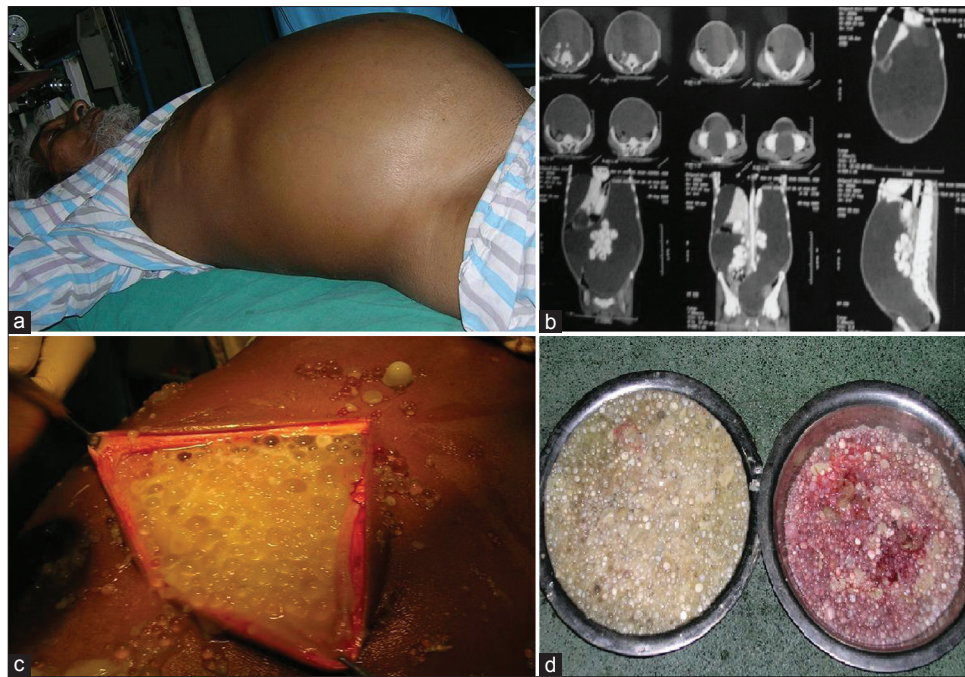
(a) Preoperative photograph of patient with symmetric enlargement of the abdomen, (b) Contrast-enhanced computed tomography (CECT) scan showing whole abdominal cavity occupied with multiloculated noncalcified content of mixed attenuation and small gut pushed posteriorly, (c) Intraoperative photograph showing abdomen filled with daughter cyst and membrane, (d) Part of the removed content of abdominal cavity
